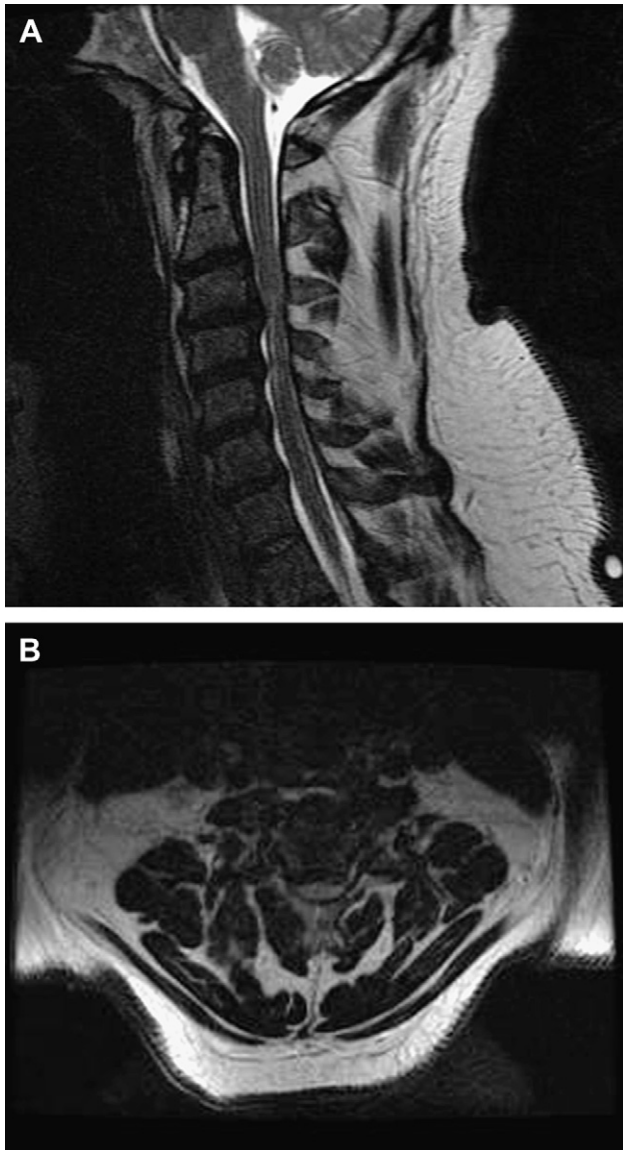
T2 sagittal (A) and axial (B) magnetic resonance imaging of a 47-year-old man who developed cervical myelopathy. Multilevel disc displacement may be seen without significant hypertrophy of the posterior longitudinal ligaments. Also evident is loss of the cervical lordosis. This combination results in compression of the cervical spinal cord.
